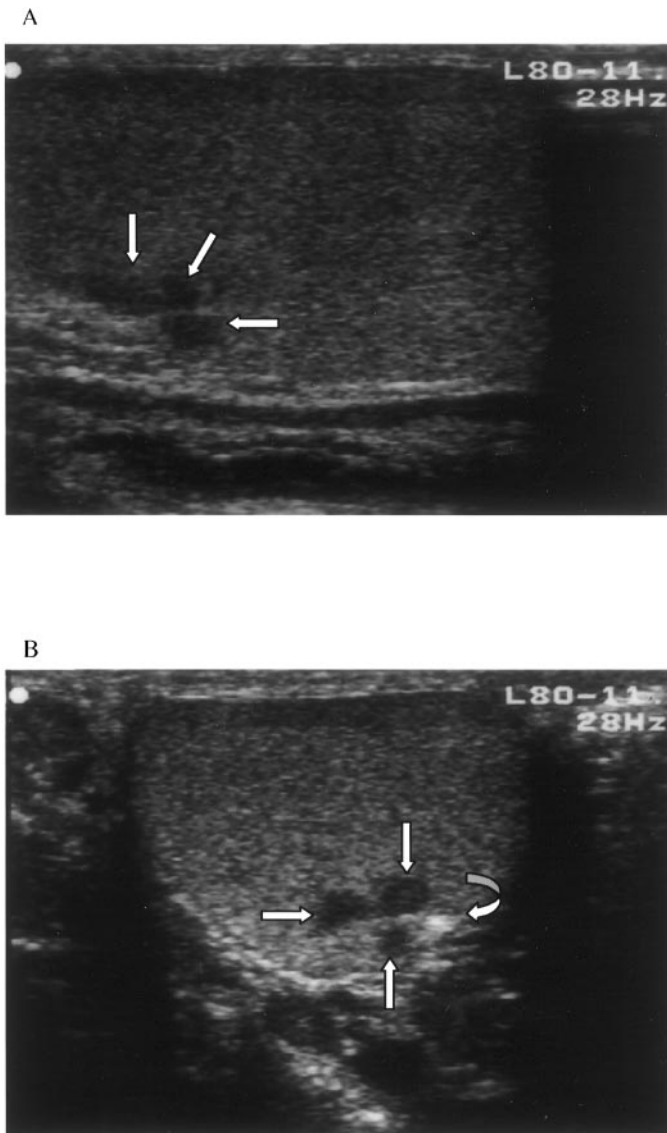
Small adrenal rest tumors in a 17.9-yr-old male patient (no. 15) with 21-hydroxylase deficiency. A, Longitudinal ultrasonographic image of the left testis in the plane of the mediastinum showing three small well delineated conflating tumors (*arrows*). The tumors are hypoechoic compared with the normal testicular tissue. Their maximal lengths were 0.4, 0.3, and 0.2 cm, respectively. B, Ultrasonographic image obtained in the transverse plane. Note that the tumors are located around the mediastinum, which is visible as a small white line (*curved arrow*).
